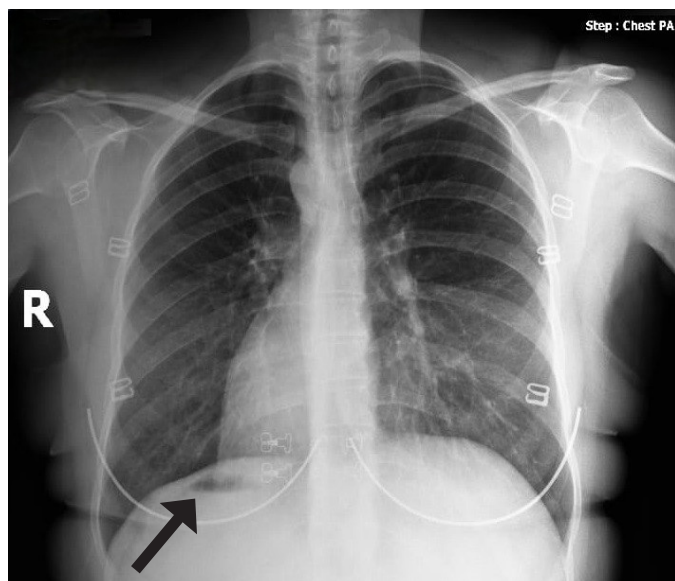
Right-sided gastric fundus air and dextrocardia appearance on chest X-ray (black arrow)
